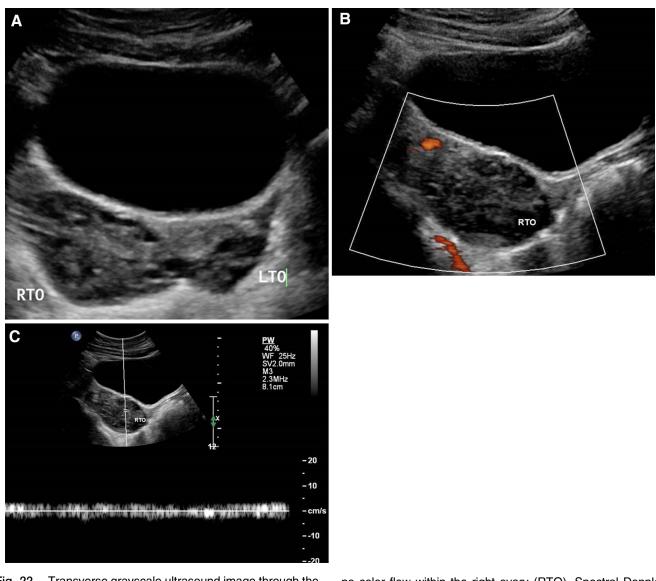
Transverse grayscale ultrasound image through the pelvis (\mathbf{A}) in a patient with abrupt onset of severe right lower quadrant pain demonstrates an asymmetrically enlarged right ovary (RTO) compared with the left ovary (LTO). Longitudinal ultrasound of the right adnexa with power Doppler (\mathbf{B}) reveals
